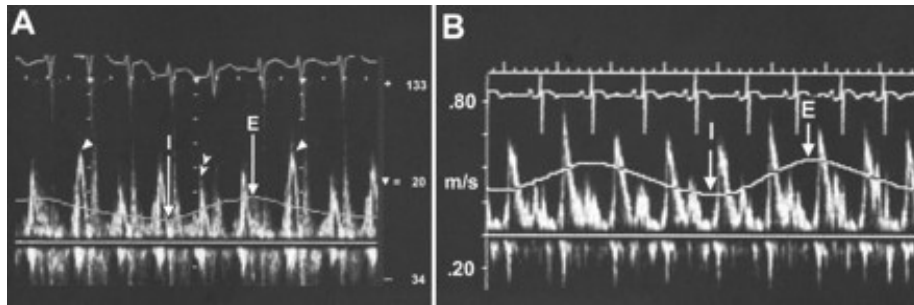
(A) Doppler findings in constrictive pericarditis. Pulsed-wave Doppler recording of the mitral inflow velocity showing a marked increase in the mitral inflow E velocity (single arrowhead) with expiration compared with inspiration (double arrowhead). (B) Follow-up echocardiogram one month later, showing no significant increase in the mitral inflow E velocity with expiration, consistent with resolution of constrictive hemodynamics. I = inspiration; E = expiration.
